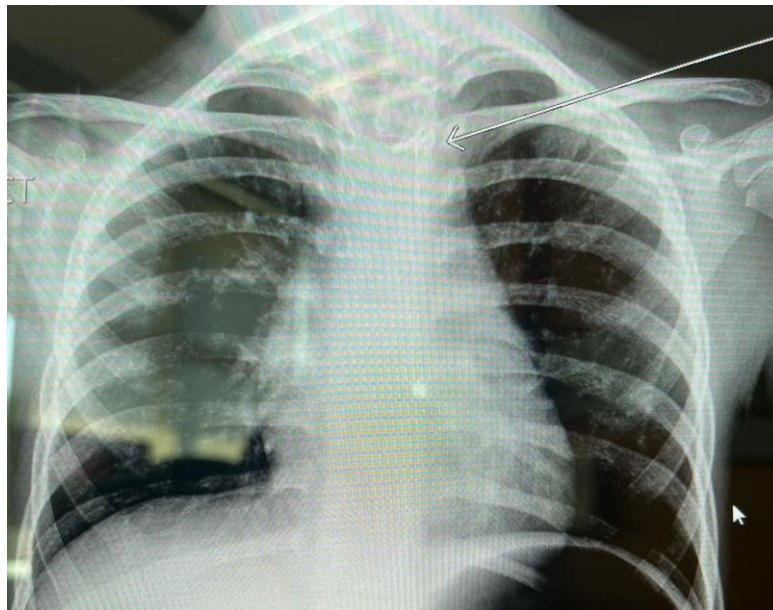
Anterior Posterior view of neck xray showed foreign body (white arrow) at level of T1-T2 vertebrae.
